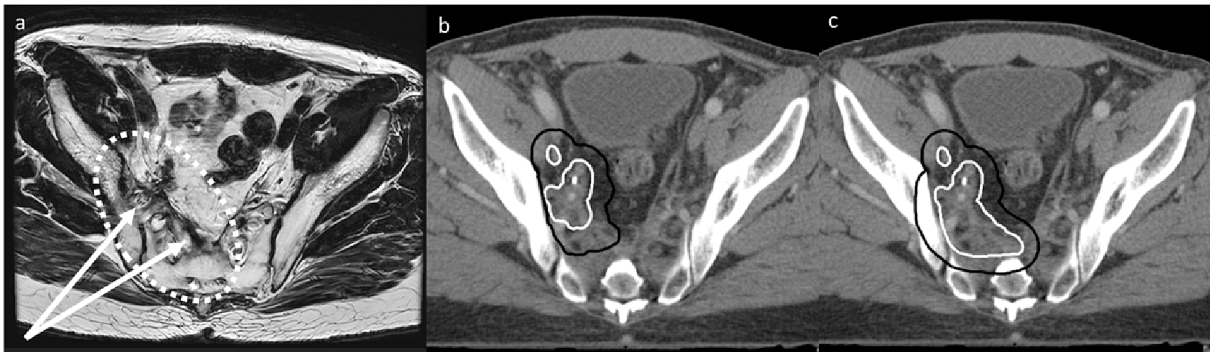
Example of altered radiotherapy target volumes after peer-review in a multifocal recurrence. It was advised to extend the gross tumour volume (white) from before (b) to after (c) to encompass complete fibrosis as seen on diagnostic MRI (a). Additionally, it was advised not to edit clinical target volume (CTV, black) towards the lateral pelvic side wall, to guarantee that surgical resection margins would be encompassed by the CTV.
